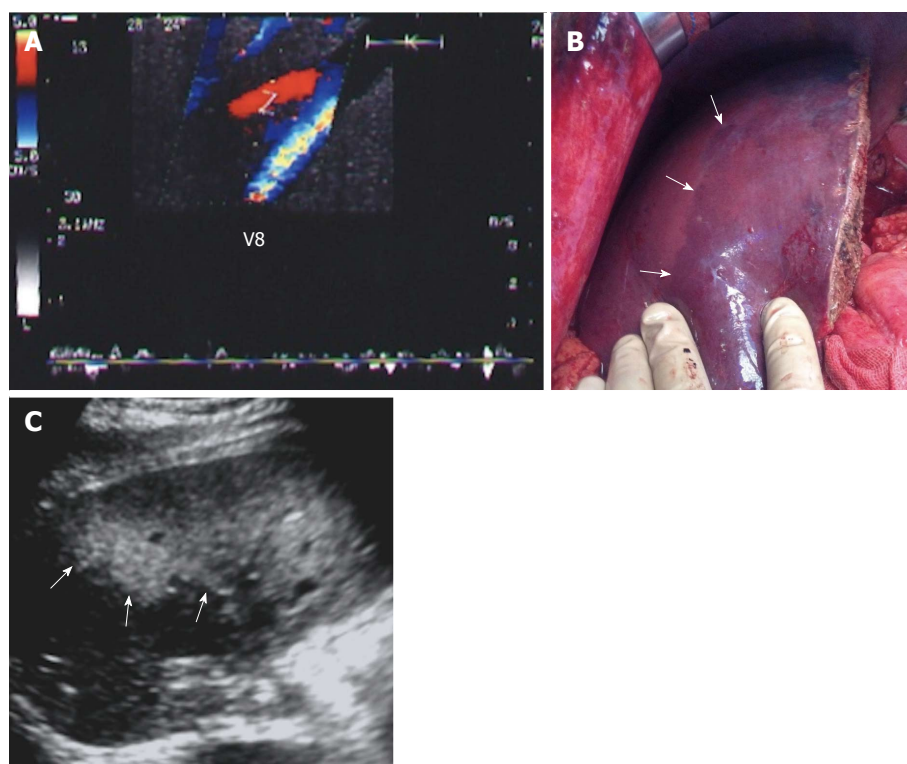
Graft congestion secondary to segment VIII vein ligation. A: Intra-operative color Doppler image showing stagnant (to-and fro flow) within a ligated V8 (normal intraoperative finding); B: Photography showing geographical areas of discoloration (congestion) along the anterior segments of the graft (arrows); C: Postoperative US image of the same patient 2 d post-operative demonstrating large, echogenic, geographical areas of congestion along the anterior segments of the graft (arrows). Associated graft dysfunction was present. V8: Segment VIII vein.
